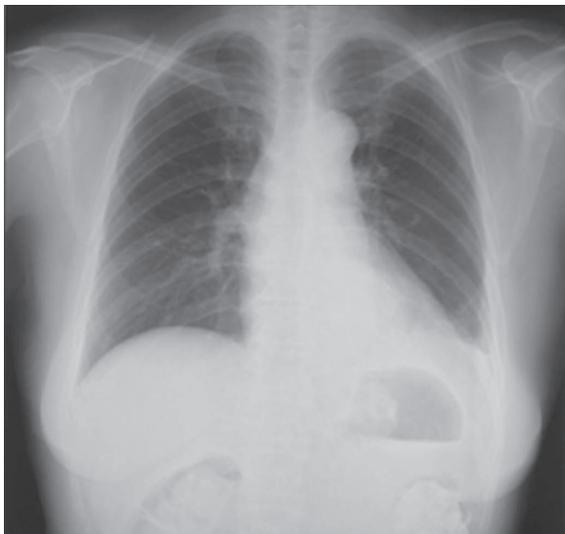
Chest radiograph revealed an abnormal shadow with an air–fluid level in the lower mediastinum.
